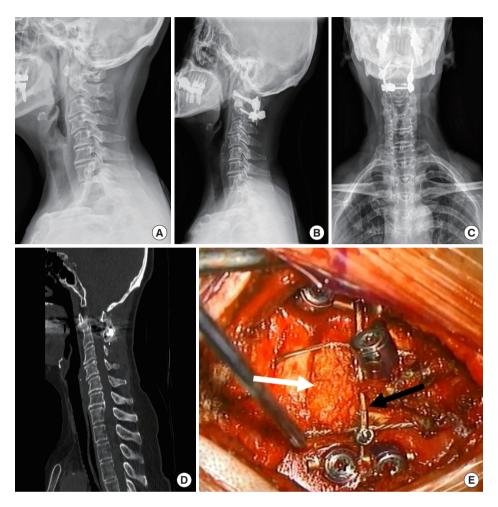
Radiologic and surgical figures of the patient treated by C1 lateral mass—C2 pars and lamina screw construct wiring interlamina with autograft bone. Preoperative lateral (A) and postoperative lateral (B) and anteroposterior (C) radiographs. (D) Midsagittal image of computed tomography after surgery. (E) Intraoperative figure represents wiring interlamina (black arrow) with an autograft bone (white arrow).
